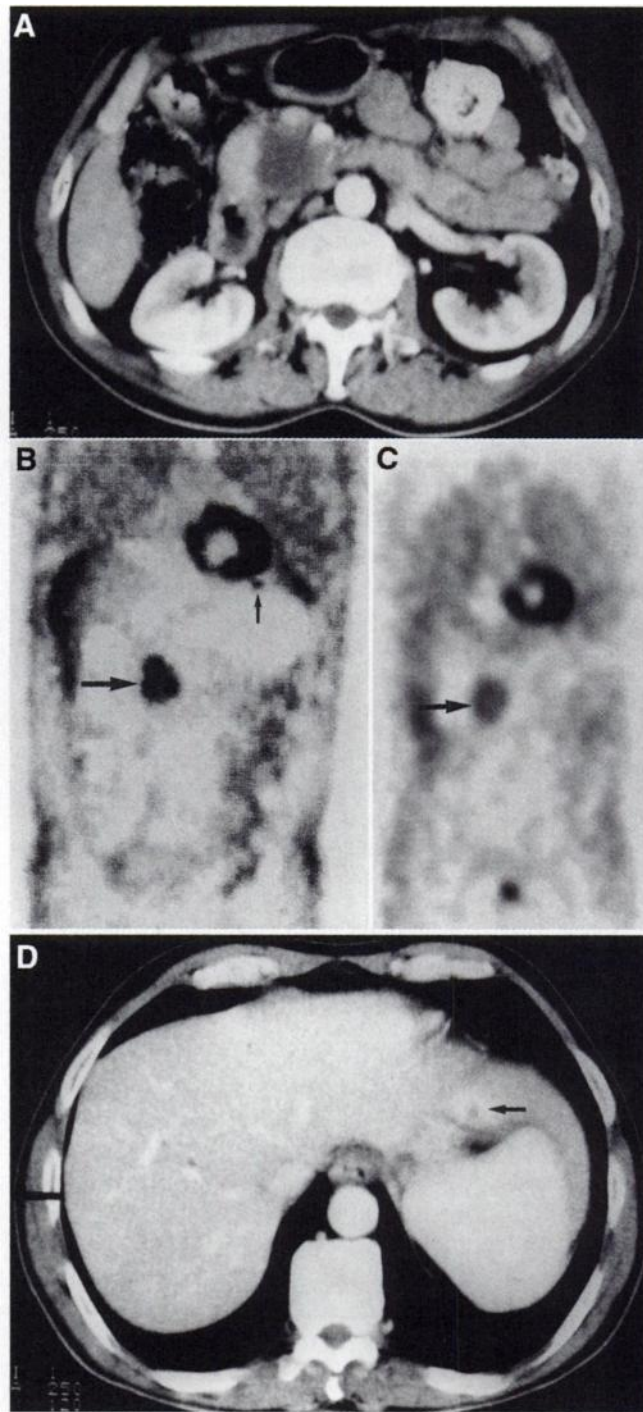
A 45-y-old man with history of biliary obstruction. (A) CT shows 3-cm lesion in head of pancreas (large arrow). (B) Coronal PET images clearly show increased uptake in pancreatic lesion and additional focus in left lobe of liver (small arrow). (C) Coronal DHC images show definite uptake only in pancreatic lesion (large arrow). (D) Repeat CT confirmed small lesion in left lobe of liver (patient B, small arrow).
